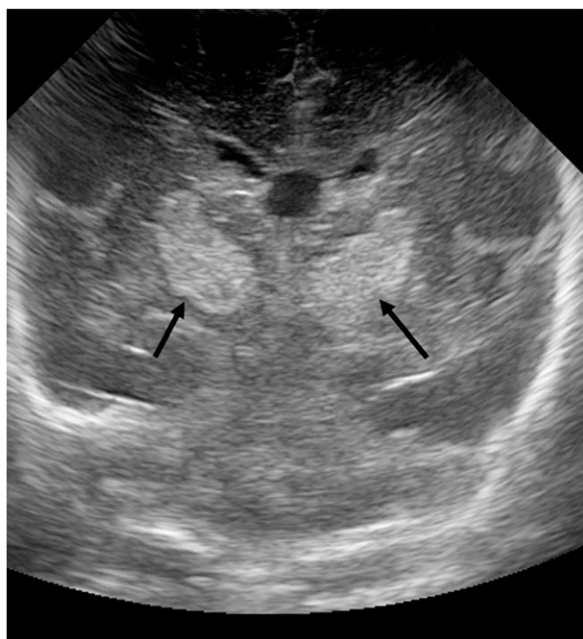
Head ultrasound 28 days after birth showing bilateral thalamic hemorrhage (arrows) and bilateral grade 1 intraventricular hemorrhage.
